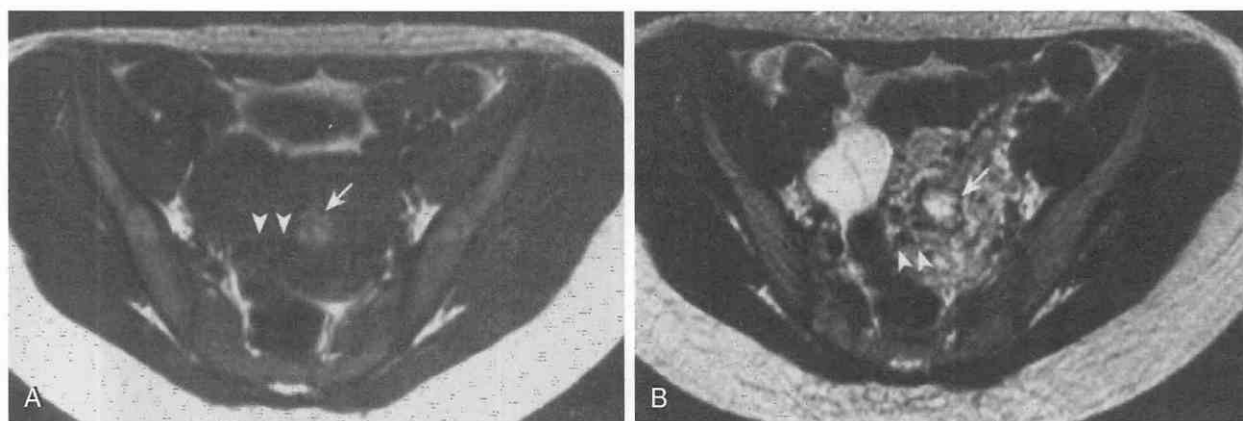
Gestational trophoblastic disease. T1-weighted (A) and T2-weighted (B) images show a high-signal-intensity mass embedded within the myometrium (*white arrows*) in a patient after evacuation of a complete mole. On the T2-weighted, spin-echo image in B, the punctate signal voids around the mass (*arrowheads*). A multiseptate theca lutein cyst is present.
